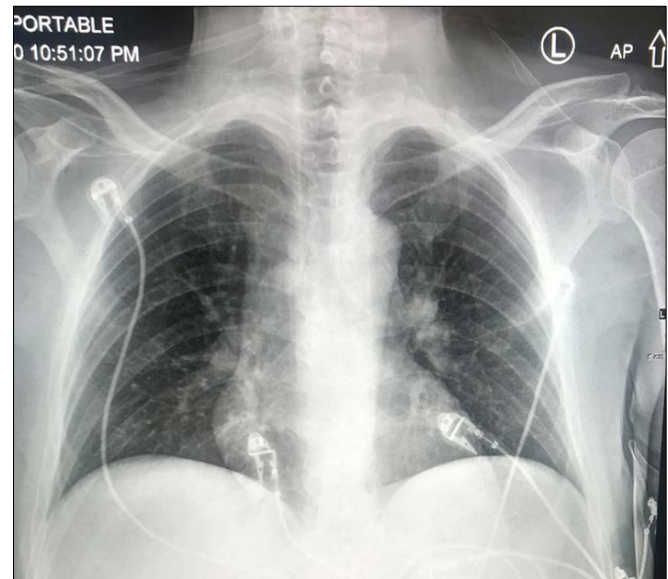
Anterior-posterior chest radiography exhibits an expanded SVC.
